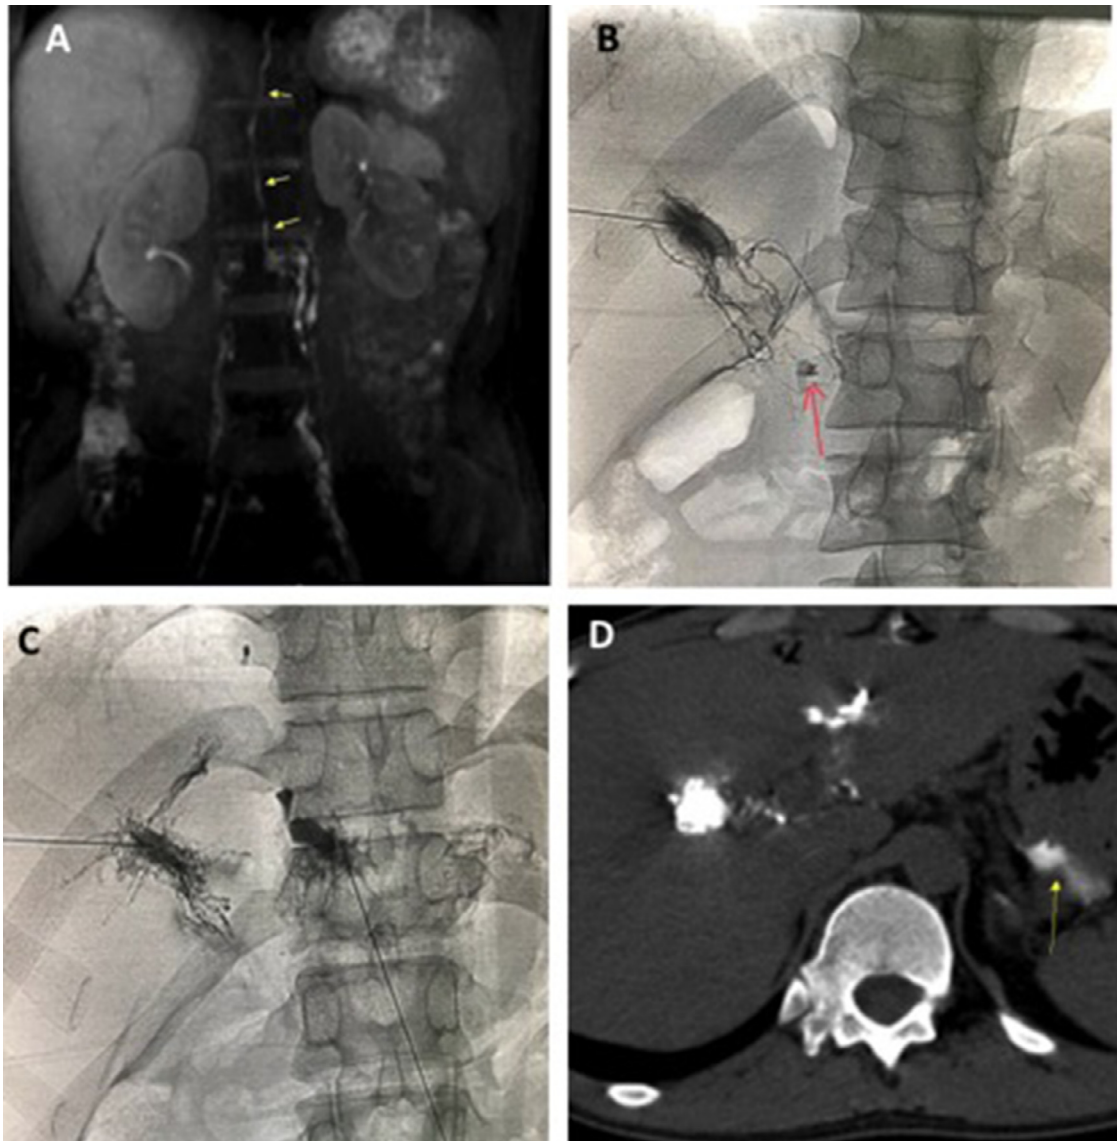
Case 1. Panel A: MRI lymphangiography showing normal thoracic duct and no extravasation of contrast. Panel B and C: Transhepatic lymphangiography showing an extravasation of contrast at the liver hilum (arrow). No contrast extravasation was seen when the left hepatic lymphatic channel was opacified. Panel D: Noncontrast CT scanner just after the procedure revealing presence of contrast in the peritoneum.
